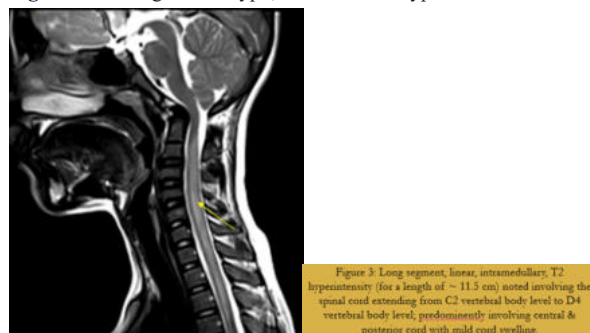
showing T2 hyperintensity on sagittal C-spine MRI.
